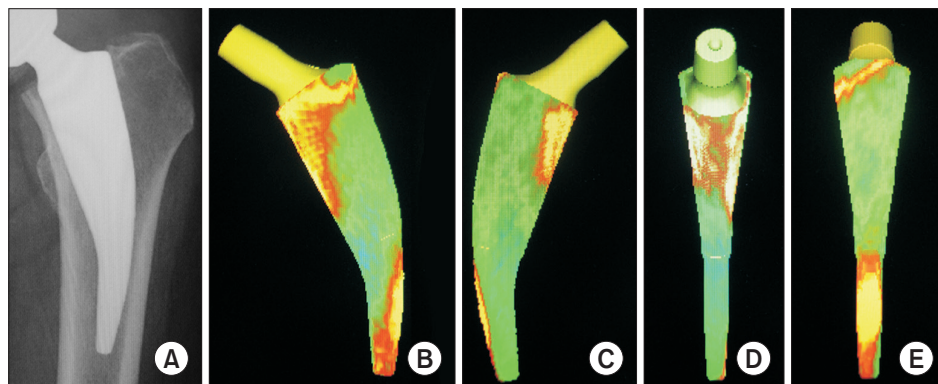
Visual assessment for Metha by density mapping. (A) Postoperative radiograph. (B) Anterior-posterior view. (C) Posterior-anterior view. (D) Medial view. (E) Lateral view.
